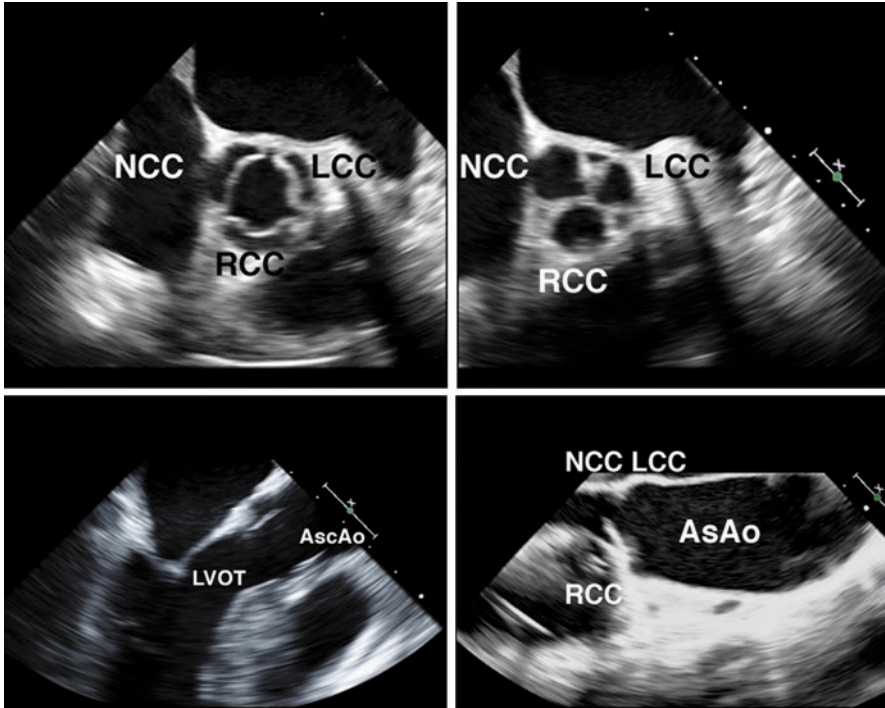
Normal Transesophageal images of aortic root, valve and ascending aorta. Upper panel is short axis view of the aortic valve in systole and diastole. NCC-noncoronary cusp, LCC-left coronary cusp, RCC-right coronary cusp. Lower panel is long axis view of the aorta showing the relationship of the ascending aorta (AscAo) to the left ventricular outflow tract (LVOT) and the coronary cusps
